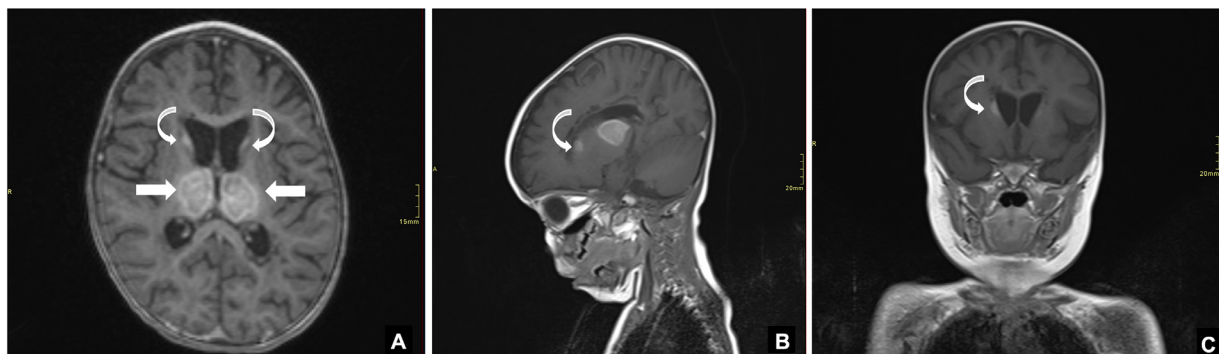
Enhanced brain MRI images axial (A), Sagittal (B) and coronal (C) Bilateral abnormal signal intensities involving both the thalami which appear relatively symmetrical. These areas show heterogeneous but avid enhancement post contrast (straight arrows). Note these signal abnormalities are also demonstrated at the bilateral head of caudate (curved arrows)
